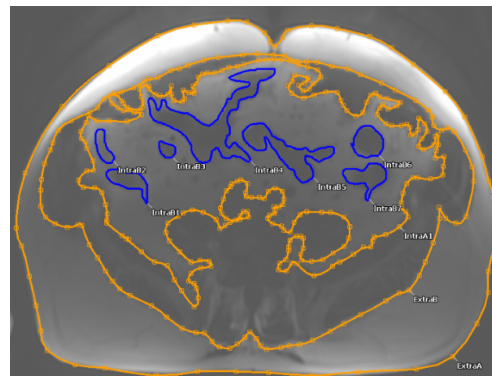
DICE T1-weighted abdominal MRI for the quantification of adiposity
